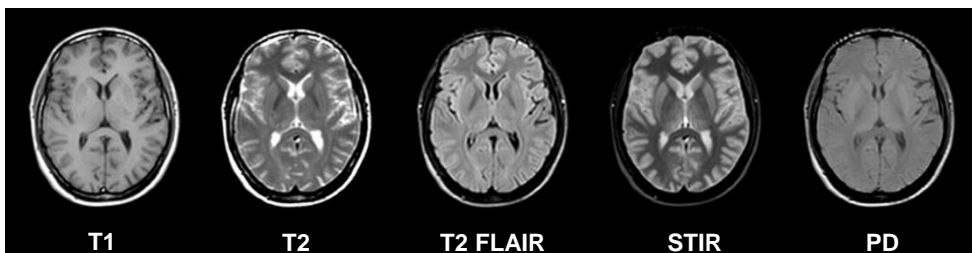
Examples of T1-weighted, T2-weighted, T2FLAIR, STIR, and PD-weighted axial images of the brain of a healthy volunteer.
